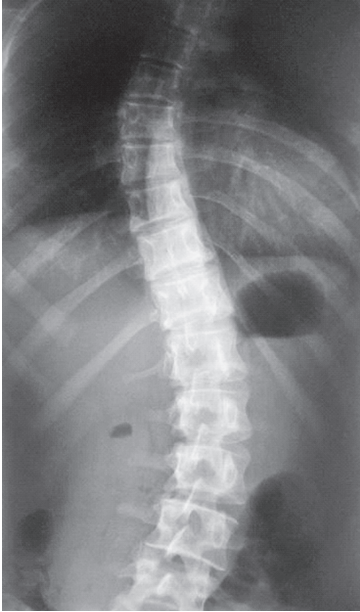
X-ray in the anterior-posterior projection of a 15 year old girl before being fitted with a corset [14]
